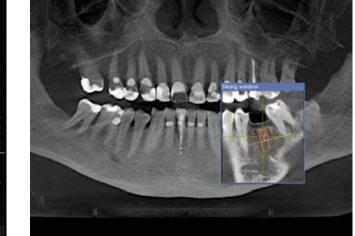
Implant planning on the CBCT base
